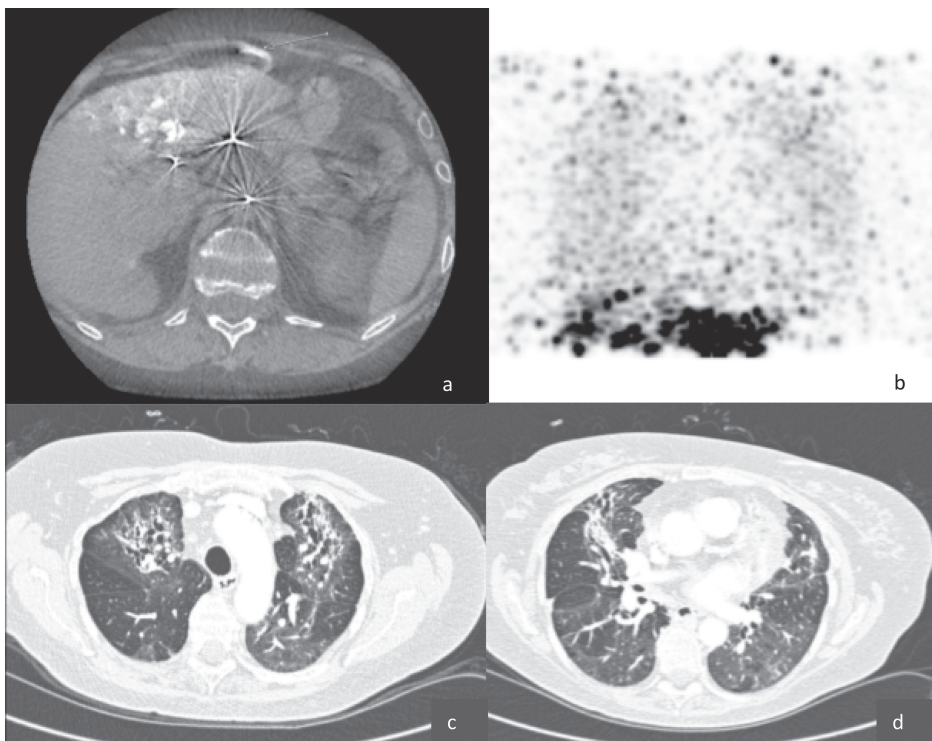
Figure 7a: cone-beam CT of 65-year old woman with HCC, with arteriovenous shunt (arrow). Figure 7b shows the lung shunt on ^{90}Y -PET. Figure 7c-d show high-resolution CT images of the lungs with ground-glass nodularities and fibrosis.
